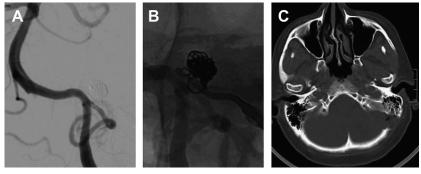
Cerebral angiography following clipping, (*A*) with and (*B*) without subtraction showing perfect reconstruction of the PICA, clip location, and the coils left inside; (*C*) postoperative computed tomography showing the retromastoid minicraniectomy.
